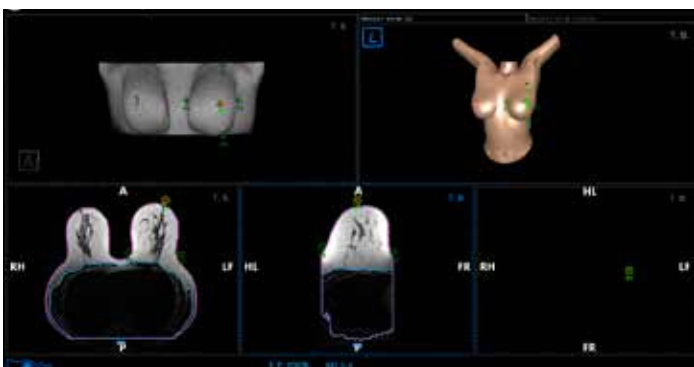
Registration between 5 anatomical superficial points on prone MRI (left) and the 3D model (right);
